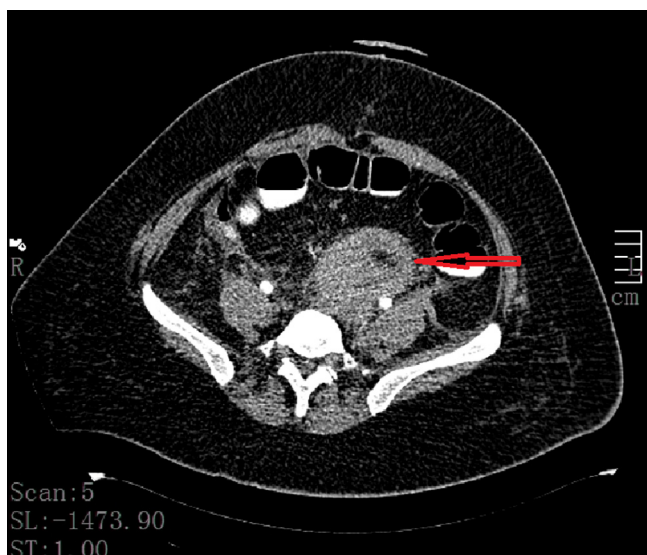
A 10 × 9 cm cystic mass surrounding left iliac artery appearance on axial computed tomography (red arrow).
